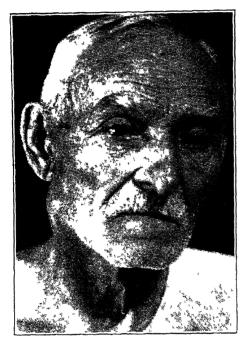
Carcinoma of a gill cleft The tumor was hard, nodulated and but slightly movable No recurrence after radical operation followed by x-rays (Courtesy, Southern Surgeon, Feb, 1937)
